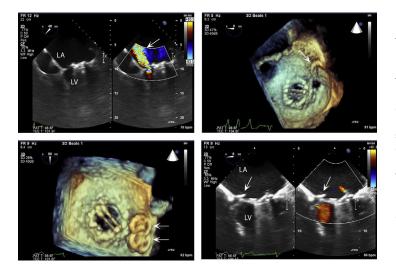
Echocardiographic imaging of paravalvular regurgitation. Transesophageal echocardiography is essential for assessment of mitral paravalvular regurgitation. Top left: Medial, paravalvular regurgitation of a bileaflet mechanical prosthesis (arrow). Top right: Three-dimensional imaging showing the defect and guidance of the steerable catheter (arrow). Bottom left: Placement of 2 AVPvascular plugs (arrows). Bottom right: Resolution of the paravalvular regurgitation (arrow). LA, left atrium; LV, left ventricle.
